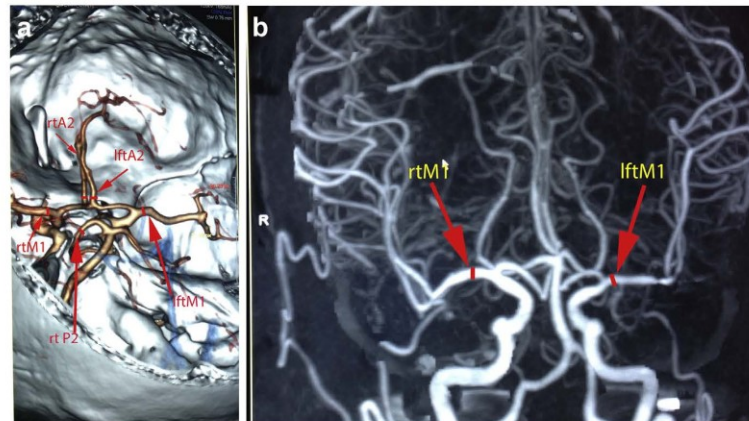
a and b: Figure showing the sites of arterial diameter measurement in reconstructive cerebral arterial Computed Tomography Angiography (CTA) and Magnetic Resonance Angiography (MRA), rt = right, lft = left, green lines showing the measurement sites of vessel diameters, A2 = the most proximal portion of second part of anterior cerebral artery and M1 = the most proximal portion of the first part of middle cerebral artery.
